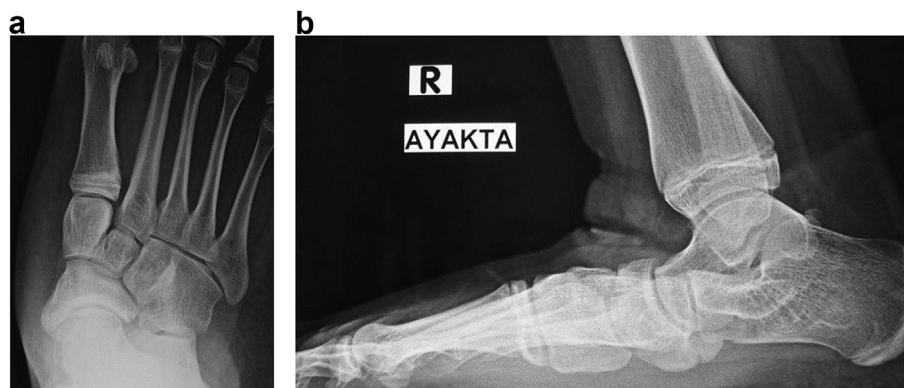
a. Preoperative anteroposterior x-ray of foot. Notice accessory navicular bone. b. Preoperative lateral x-ray of foot. Notice accessory navicular bone and talar sag.
